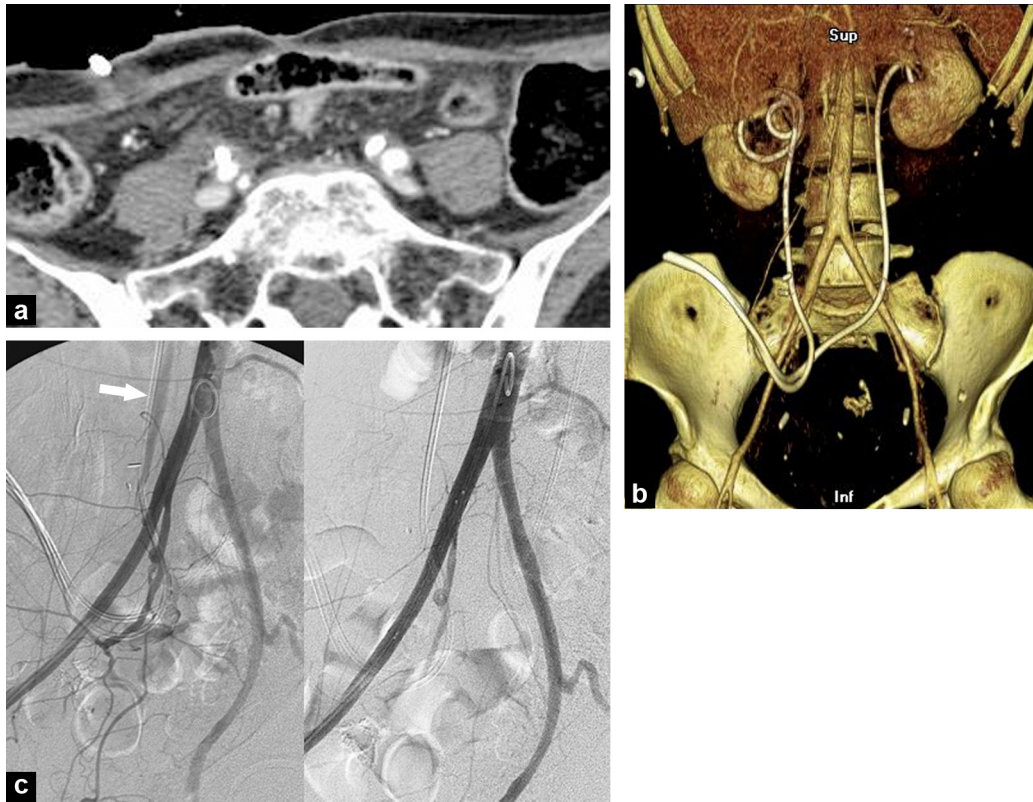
Macroscopic hematuria in a female patient with a previous history of cervical cancer with radiation-induced ureteric damage treated by long-term ureteric bypass: a: CT after enhancement, axial view performed at that time of the bleed not shown extravasation of vascular contrast to the ureters; b: CT after enhancement with volume reconstruction showing the anatomical relationships of the ureteric catheters and two iliac arteries; c: hemostatic embolization. Arteriography shows the fistula between the origin of the right external iliac artery and the ureter (arrow). After deploying a coated stent the arterio-uroteric fistula is abolished.
